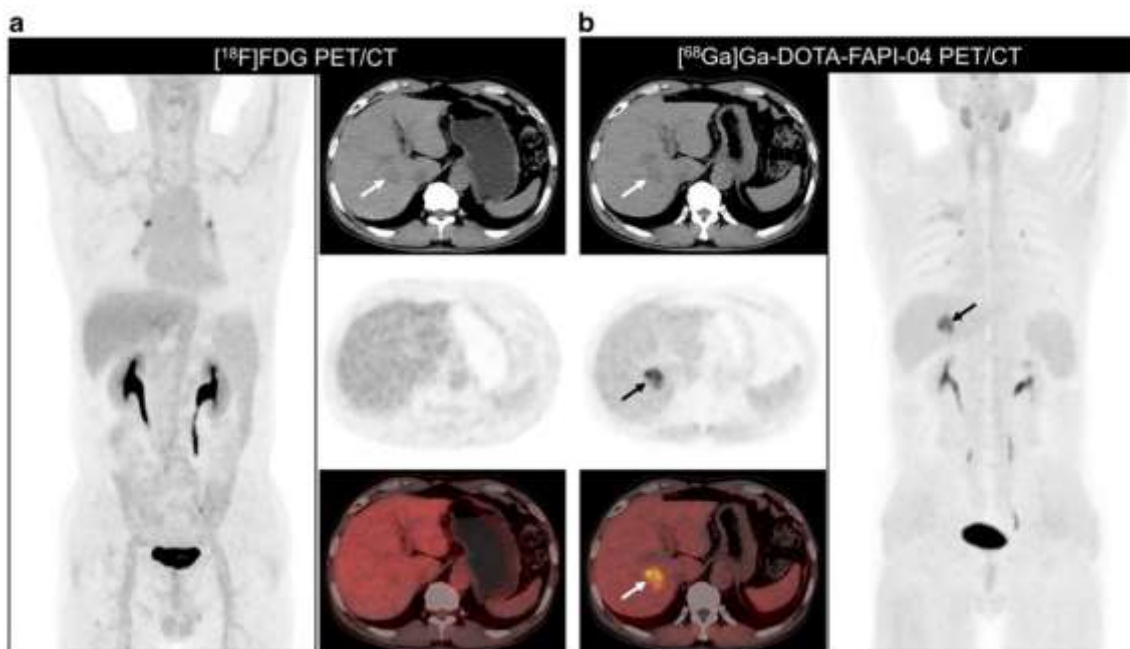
A 69-year-old man who presented with a 3-history of abdominal discomfort and previous ultrasound revealed suspicious liver nodule in the right lobe. This patient underwent PET-CT scan with ^{18}F -FDG for differentiation of the underlying malignancy. However, no abnormal activity was observed on the maximum intensity projection (MIP) and axial
